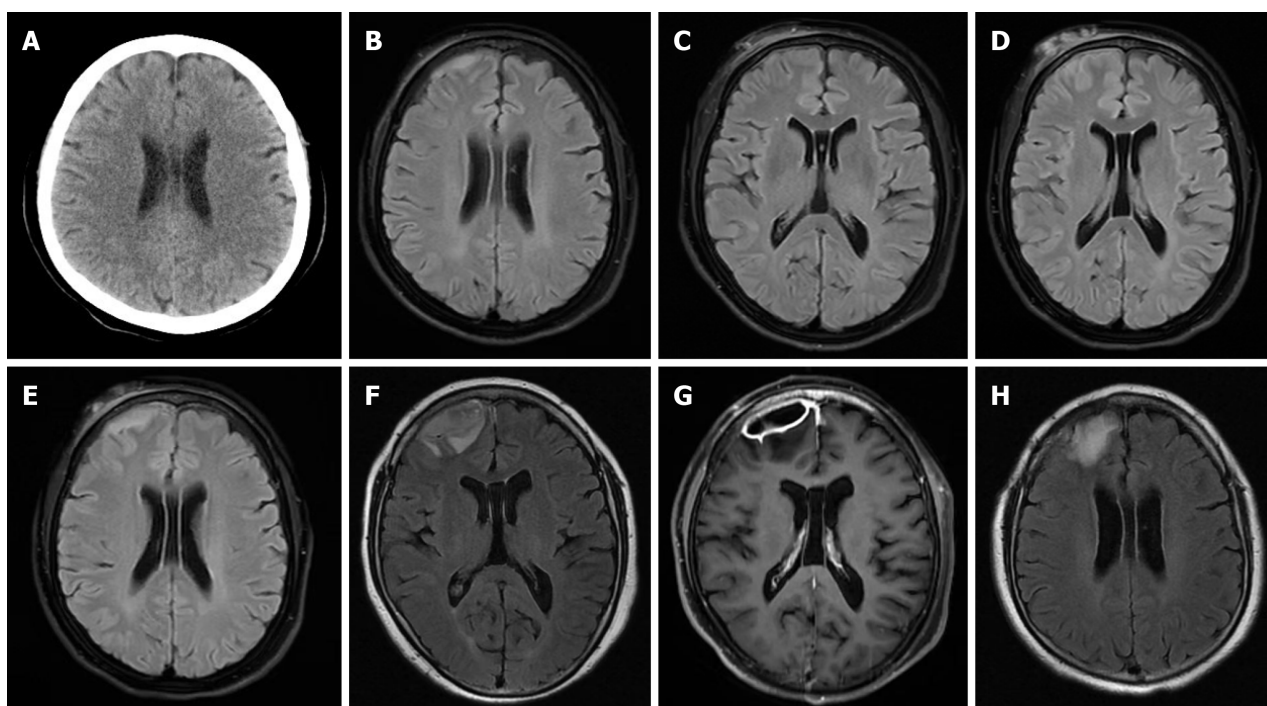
The patient presented radiographic features of neurological melioidosis. A: Head computed tomography measurements were normal; B: Brain magnetic resonance imaging (MRI) suggesting subdural hematoma; C: The right frontal skin showed swelling; D and E: A second brain MRI showed that the subdural hematoma and subcutaneous swelling at the right frontal region worsened; F: The third brain MRI showed an exacerbation of the subdural lesion in the right frontal lobe, with unclear demarcation between the lesion and the right frontal lobe, suggesting an intracranial infection; G: Enhanced MRI indicated the formation of a subdural abscess in the right frontal lobe; H: Two months post-surgery for an intracranial abscess, brain MRI showed gliosis at the surgical excision site.
